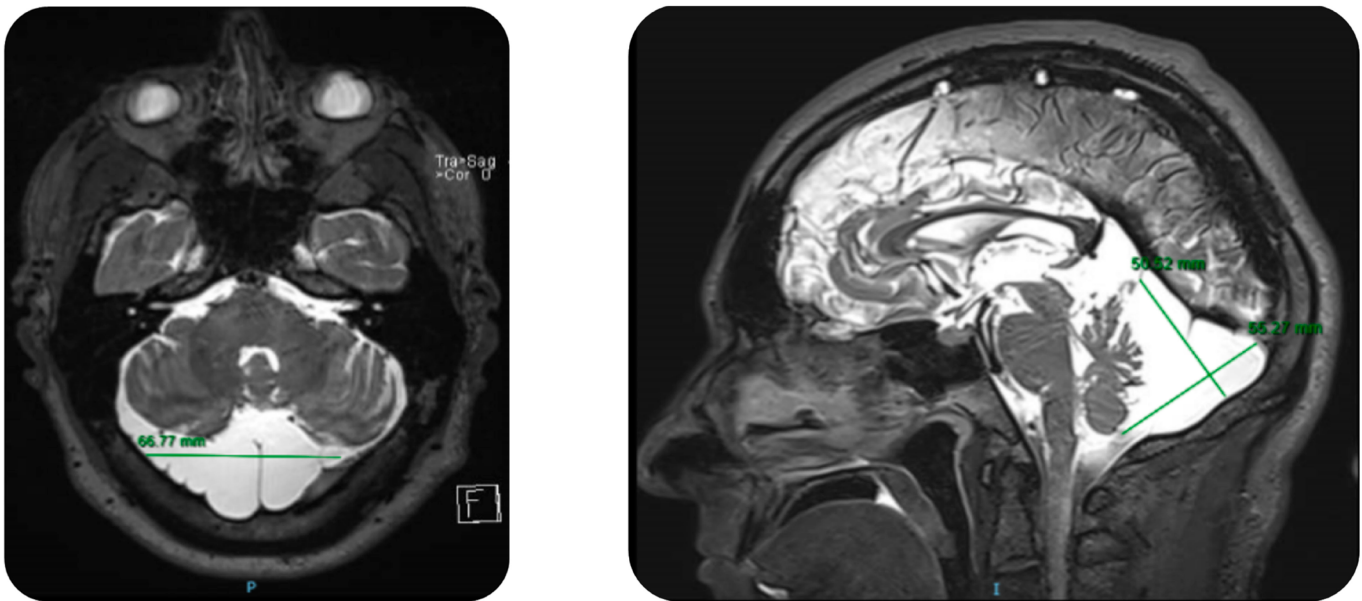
MR imaging of the brain; axial and sagittal image in T2 sequence. A large lobulated and septate retrovermian cyst is observed in one case of ARSACS where measurements were made.
